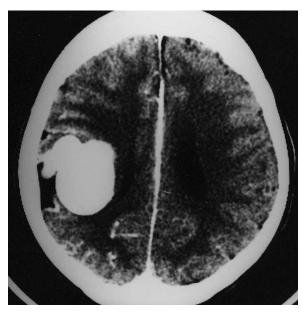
CT with contrast-Homogeneous enhancement by the contrast medium at the round lesion on the right rolandic area.
